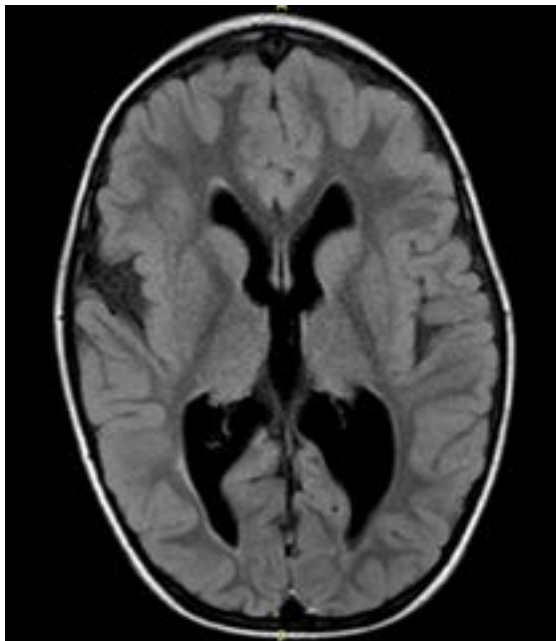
Axial FLAIR brain MRI disclosing cerebral atrophy and mild colpocephaly.
